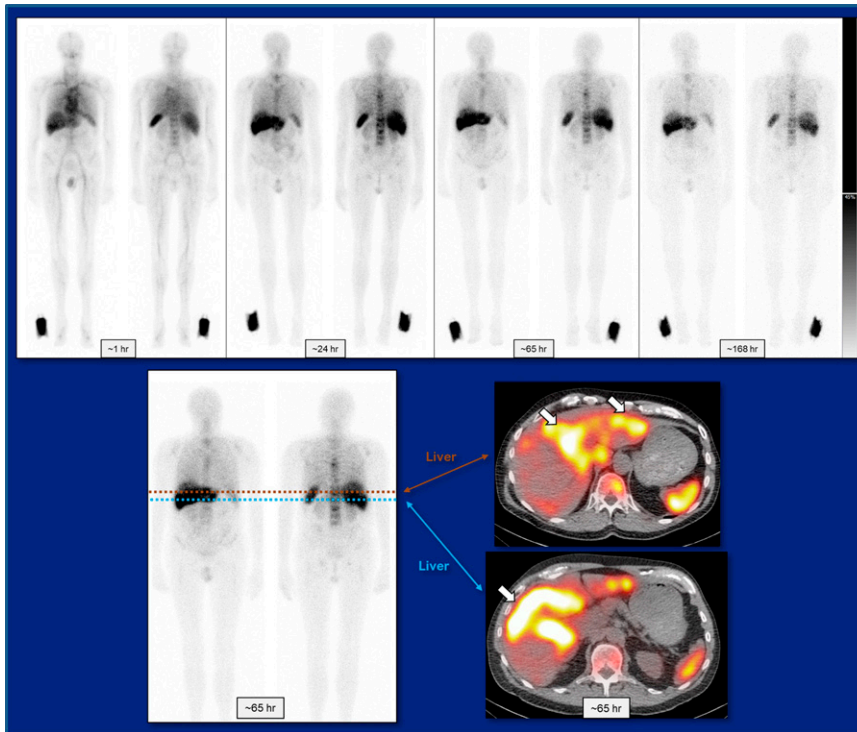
First-in-human phase 1 study evaluating efficacy and safety of ^{225}Ac -FPI-1434 in patients with insulin-growth factor type-1 receptor-expressing solid tumors. Images acquired in a 69-year-old man with castrate-resistant prostate cancer and liver metastasis. Top: Paired anterior/posterior images acquired at (left to right) 1, 24, 65, and 168 h after injection. Bottom: Corresponding SPECT/CT views of the liver at 65 h. The study emphasized the promise of theranostic pairs that facilitate patient-specific treatment planning.
